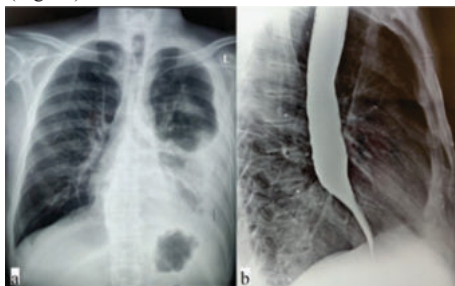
X-ray Chest Showing Left Pleural Effusion With
